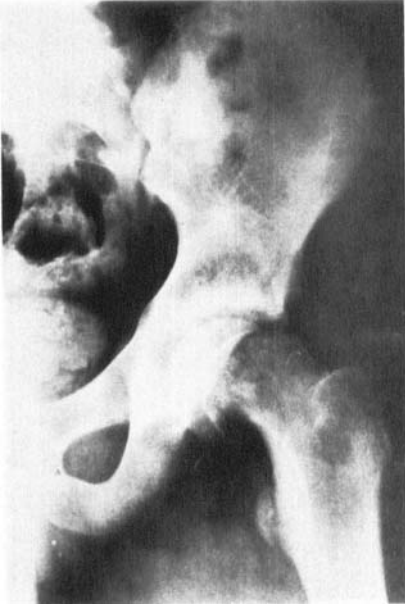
a. Roentgenological examination of the left hip joint of a 14-year-old boy (No. 6), a few hours after a minor trauma to the left hip, showing pronounced slipping.
